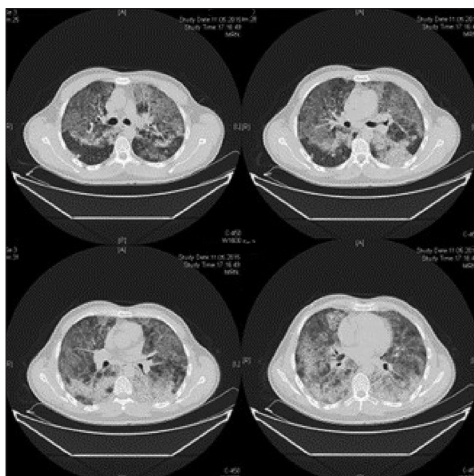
Computed tomography scan showing crazy-paving ground-glass opacity superimposed septal thickening
